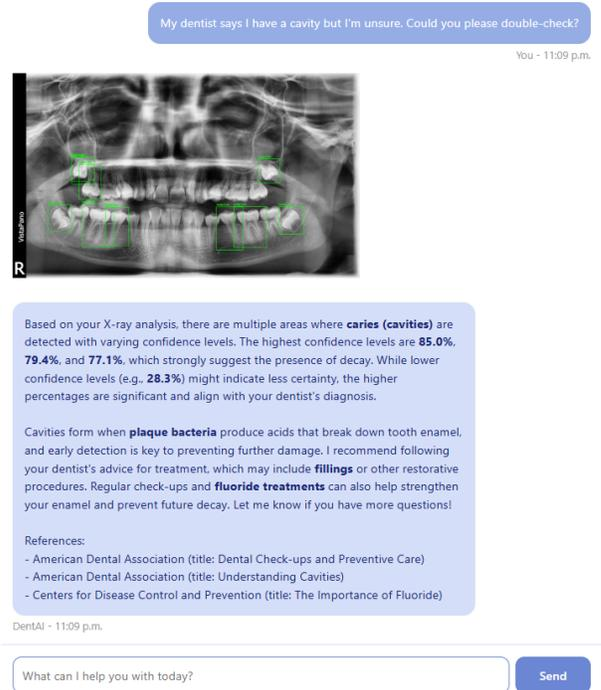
Example of chatbot response explaining detected anomalies on the X-ray. The chatbot provides insights using references from accredited sources to enhance user trust and transparency.
